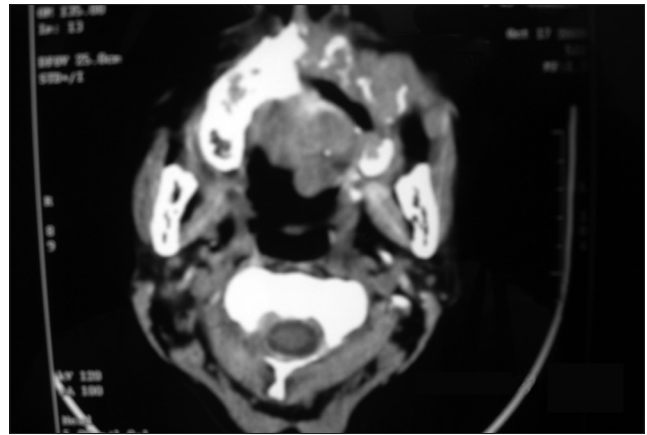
CT scan coronal view
